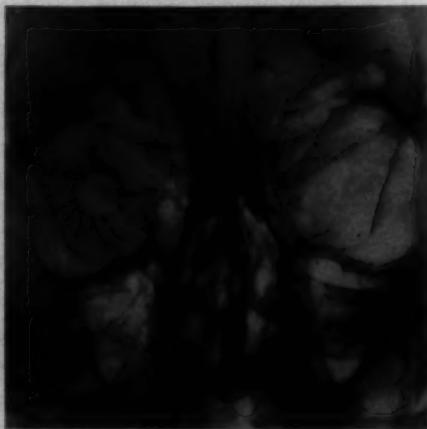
(Worst). Frontal view of scleral needles with limbal ring. Reference to the side view (fig. 2) will prove that there is still X-ray parallax.
